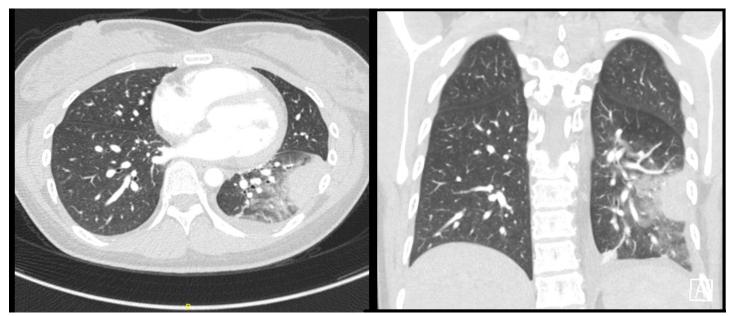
Admission CT chest with contrast demonstrating dense consolidation with air bronchograms in the apical segment of the left lower lobe and trace left pleural effusion.
